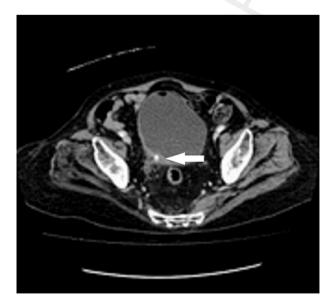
CT scan, cross section: the tip of the vesicoureteric catheter within the right vesicoureteric junction.
